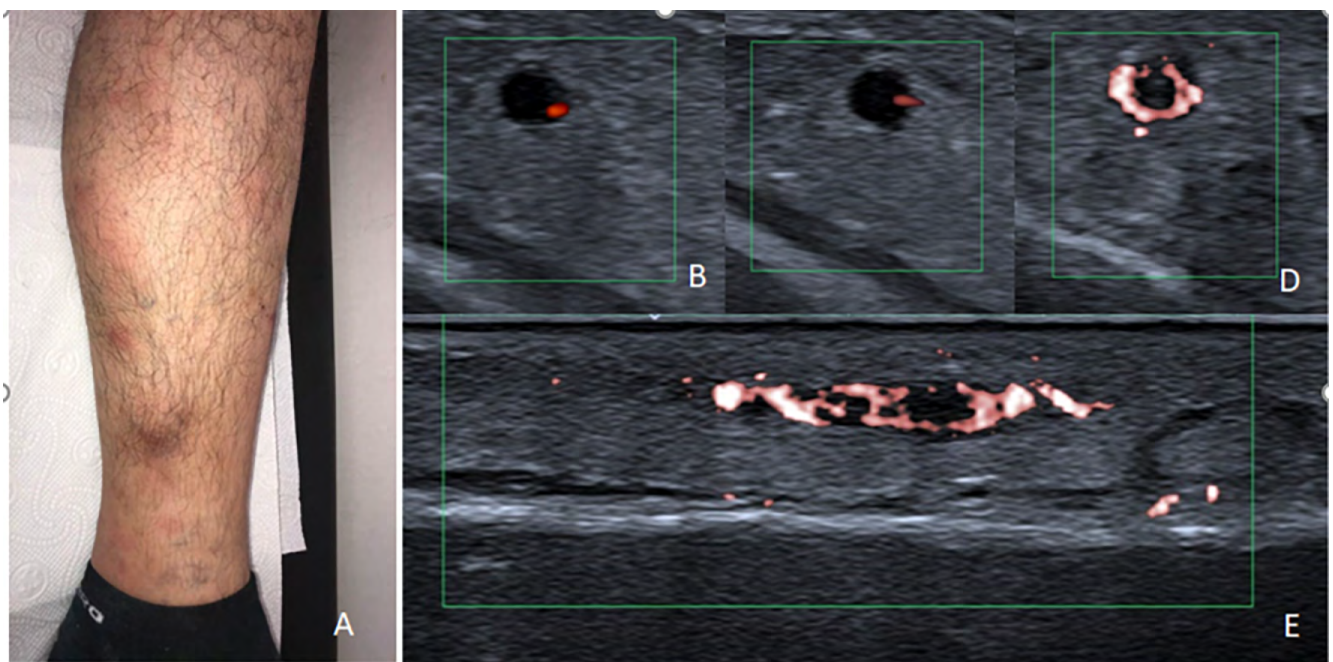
A-Nodul-like lesion on the posterior side of the cruris, B-Color Doppler US, C- Power Doppler US, D- Venous halo sign in axial plane SMI, and E-Venous wall inflammation in longitudinal plane SMI
